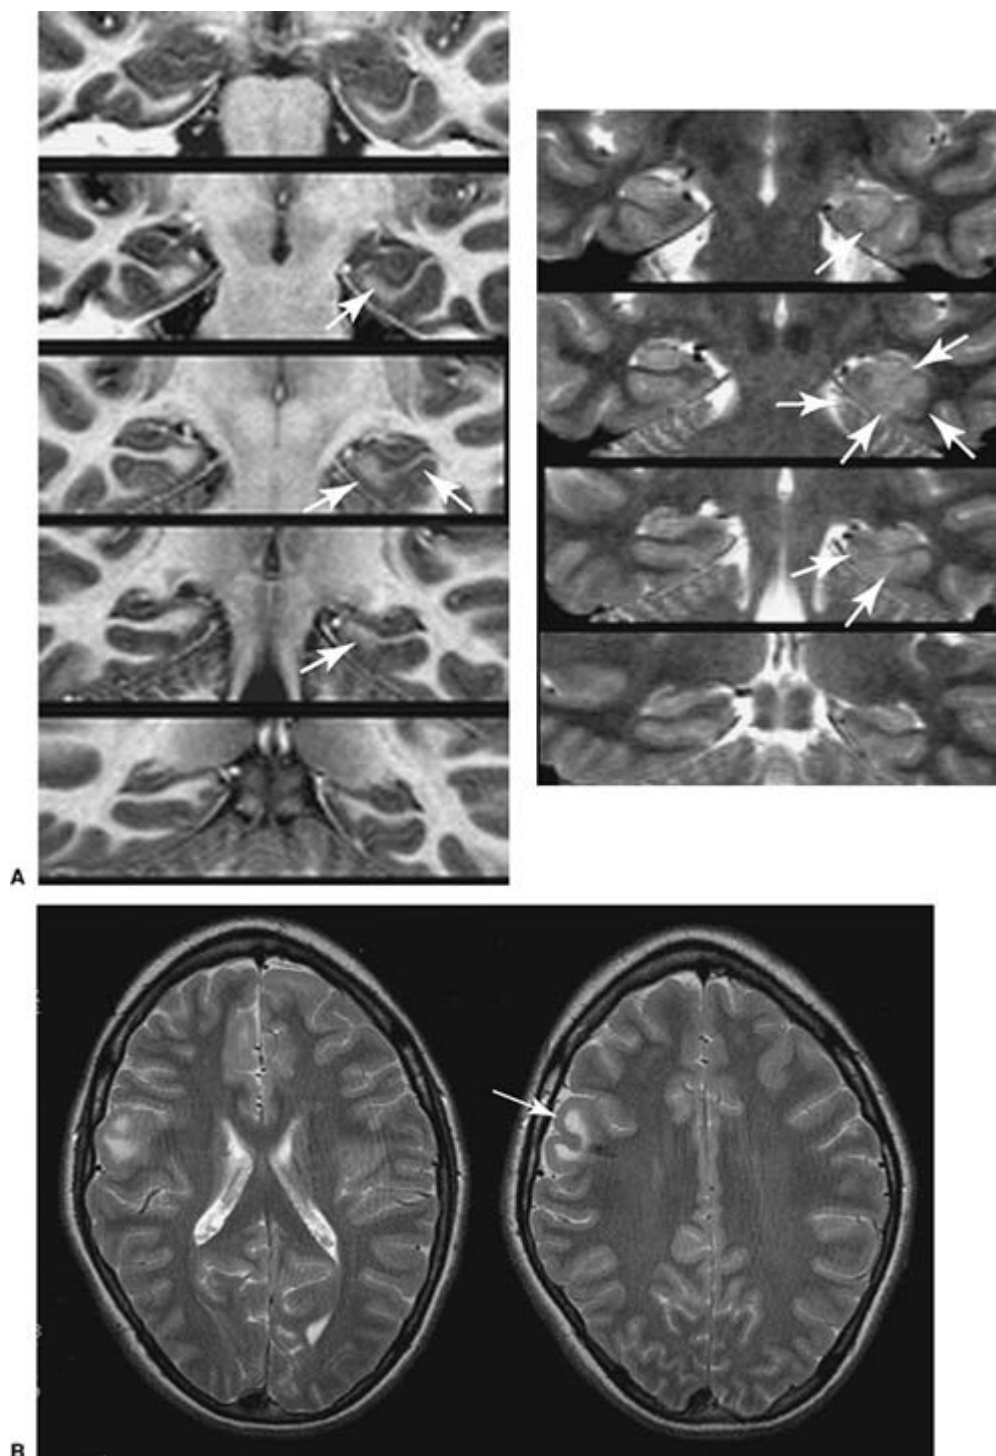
A: This 31-year-old woman with epilepsy demonstrates one of the problems of seizure localization in the mesial temporal lobes, particularly in the parahippocampal gyrus. This woman had confusing lateralization of her temporal lobe seizures. Depth electrodes were implanted in the mesial temporal region anteriorly, and these showed independent bilateral seizures more from the right. The ictal single photon emission computed tomography also showed bilateral seizures more from the right. Eventually a resection of this lesion was performed, and she became seizure free with persisting auras. In general, when there is disparity of the electroencephalographic data and an apparently epileptogenic lesion, we believe that seizure freedom is rarely achieved without resection of the lesion. The obvious and difficult issue is to recognize when lesions are truly incidental and irrelevant to the epilepsy. B:
